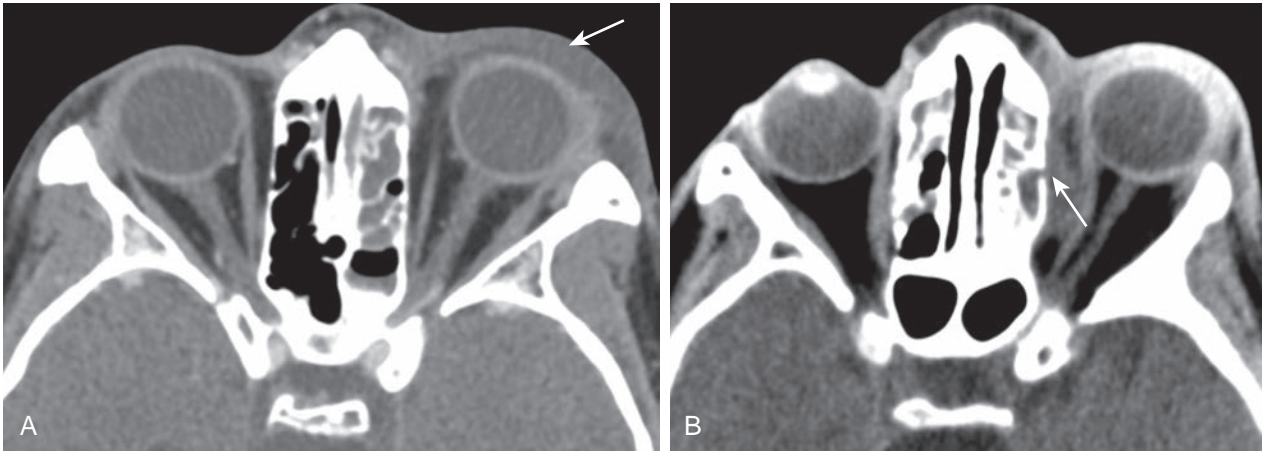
Periorbital and orbital cellulitis. (A) CT image of periorbital cellulitis from adjacent sinusitis demonstrates preseptal soft tissue swelling (*arrow*). (B) CT image of orbital cellulitis demonstrates a subperiosteal abscess with cortical dehiscence of the ethmoid wall (*arrow*) and adjacent postseptal inflammatory changes.
